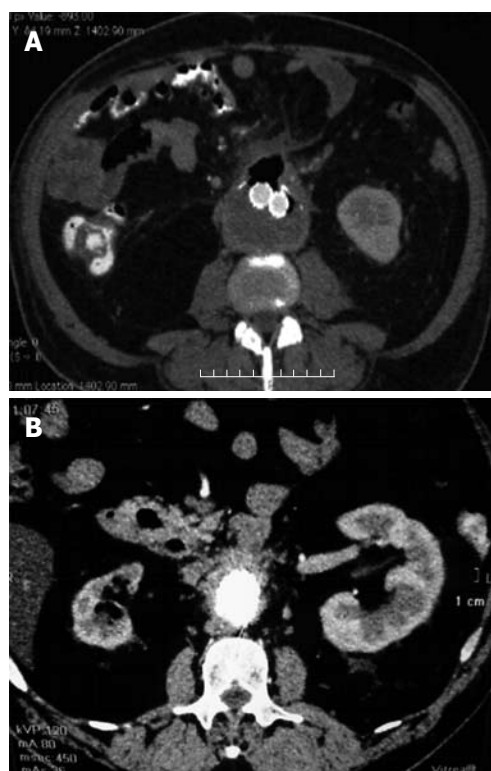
Control computed tomography angiography. A: Control computed tomography (CT) angiography shows no endoleaks and reduction of thrombotic mass volume in the aneurysmatic sac with persistence of gas collection; B: Control CT angiography after 6 mo showed no endoleaks and near total reduction of thrombotic mass in the aneurysmatic sac, without gas collection.
